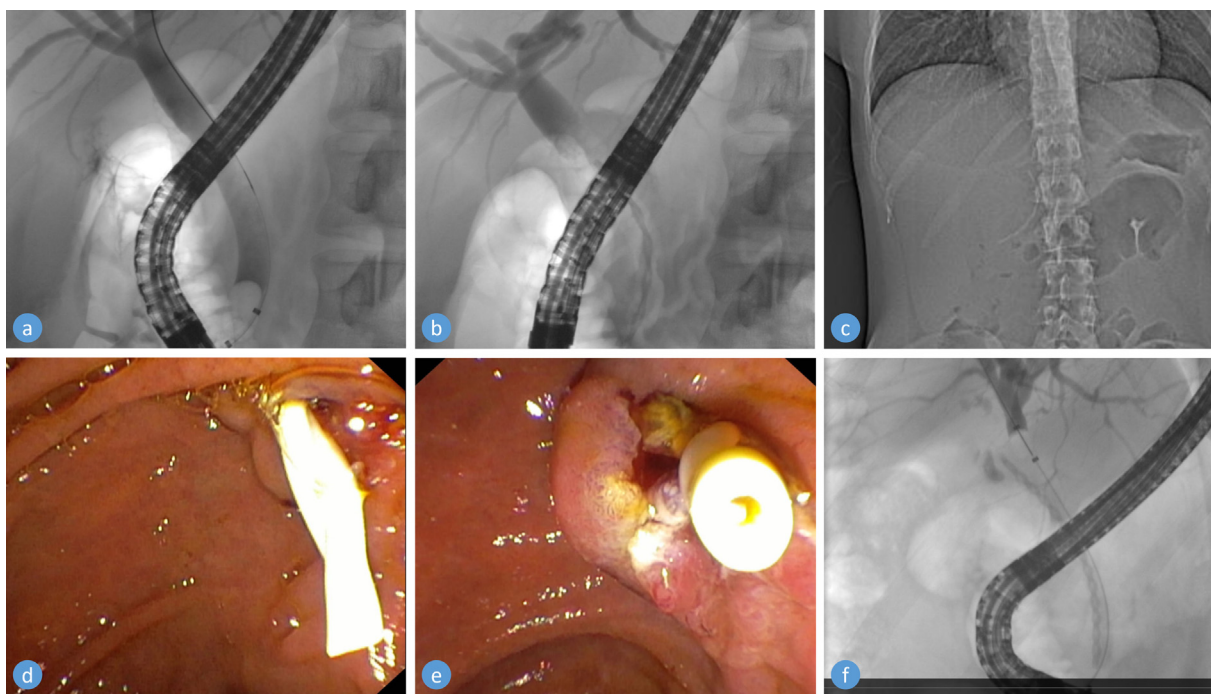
(a-d) Bridging to cholecystectomy in a 27-year-old woman (ASA I) with symptomatic choledocholithiasis. (a) Dilation assisted extraction of a single stone in the common bile duct on fluoroscopy. (b) 10 Fr x 8 cm biliary BPB stent placed as bridging to cholecystectomy. (c) 10 Fr x 8 cm biliary BPB stent on radiography. (d) 10 Fr x 8 cm biliary BPB stent in endoscopic visualization. (e-f) Stent dislocation in a 78-year-old man (ASA III) with biliary pancreatitis. (e) 10 Fr x 10 cm biliary BPB stent placed as bridging to cholecystectomy. (f) BPB stent dislocation into the cystic duct. BPB stent, biodegradable pancreaticobiliary stent.
